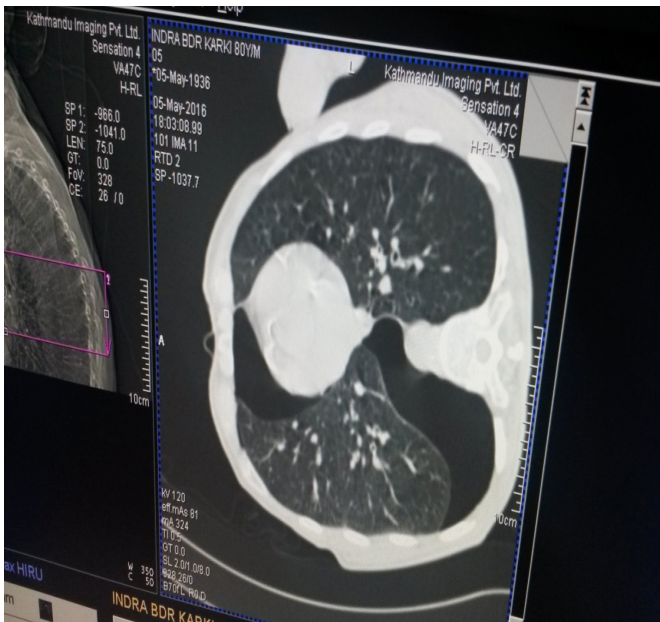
CT shows presence of pneumothorax
